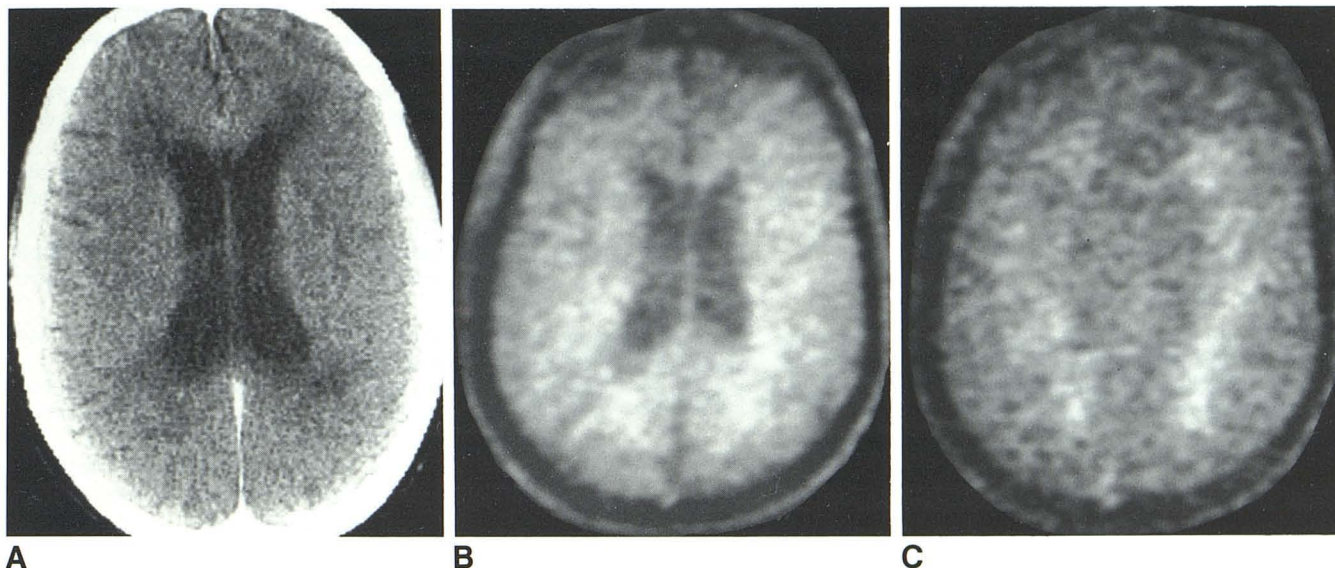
Diffuse end-stage chronic plaques. A, Delayed enhanced CT scan. Diffuse, bilateral, nonenhancing, low-density lesions in white matter. (Moderately severe atrophy in this patient is not seen here.) B, Early CPMG image
